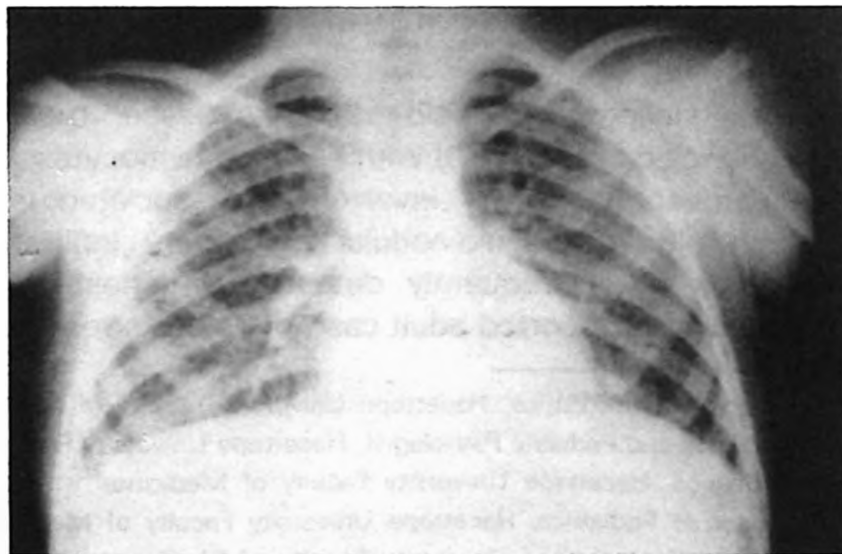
Case 1- Chest X-ray showing reticulo-nodular appearance of lung fields.
